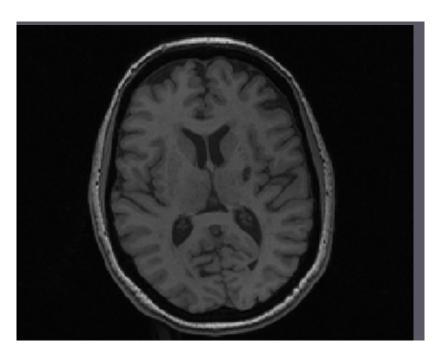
T1 weighted structural MRI: image shows stage 1 before removing the skull.
